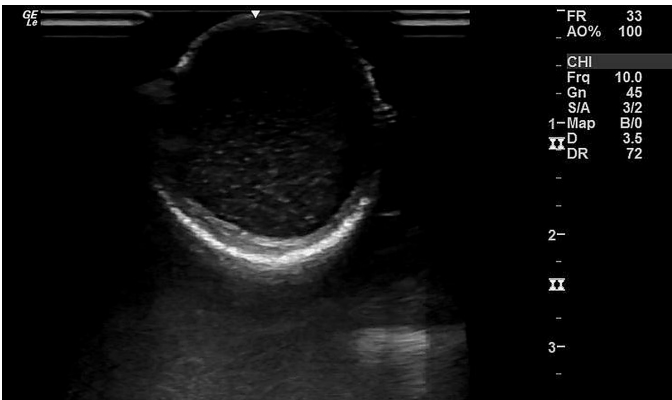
22-MHz ultrasonography: “snowfall sign.”
